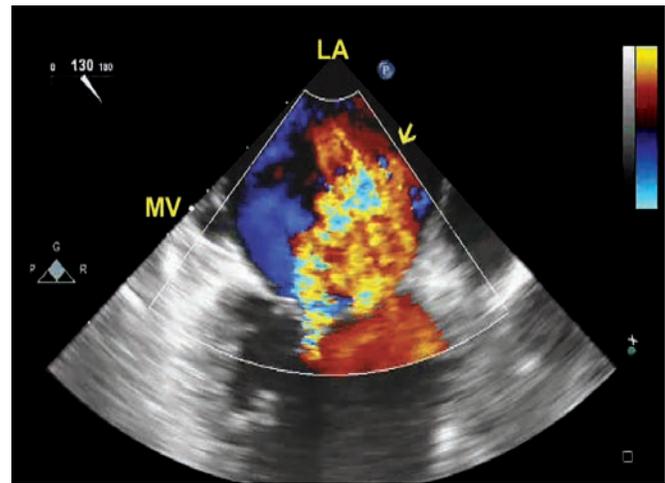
Transesophageal echocardiogram at mid esophagus level. Color Doppler imaging shows mitral regurgitation (MR) (arrow).
